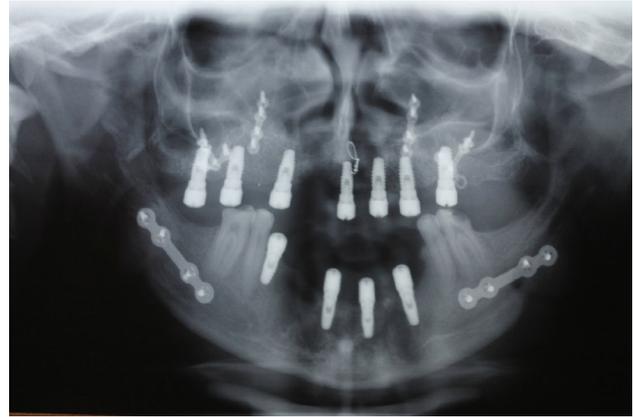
Initial panoramic radiograph before teeth extraction.
